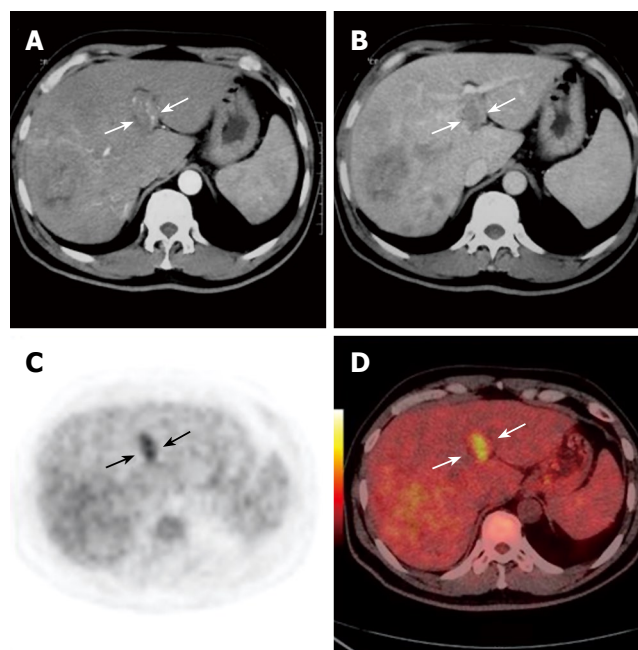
Contrast CT scan showing right lobe and caudate lobe mass and portal vein thrombus in a 55-year-old man. During the arterial phase, the thrombus appears as an iso- to hypodense intraluminal area with dense linear enhancement (white arrows, A). A filling defect was detected in the left branch during the portal phases (white arrows, B). PET (black arrows, C) and PET/CT fused images (white arrows, D) reveal a highly metabolic thrombus in the left branch.
